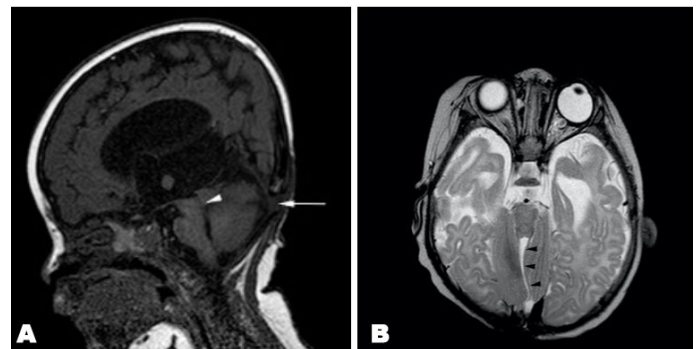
Sagittal and coronal T1-weighted imaging. Gross lateral and third ventriculomegaly with stenosis of the aqueduct of Sylvius (arrowhead). A small midline defect can be seen in the occipital bone. (A) A prominent massa intermedia is noticeable. (B) The fourth ventricle is small, with a cerebrospinal fluid-filled tract extending from it to the surface of the cerebellum (arrowheads).
